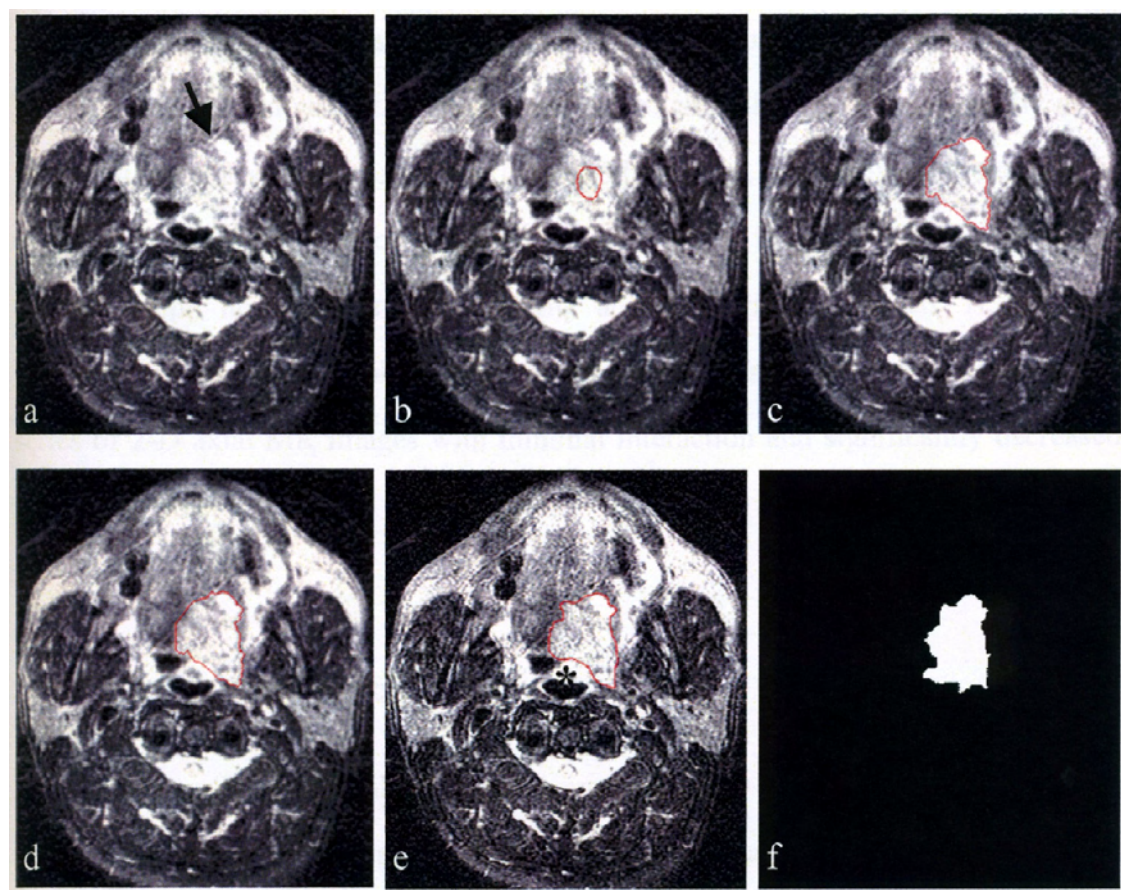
(a) Original T2W MR image with motion blur; (b) Initial boundary; (c) Result after region deformation; (d) Result after contour deformation; (e) Boundary traced by radiologist; (f) Result using the unsupervised hierarchical segmentation method.
